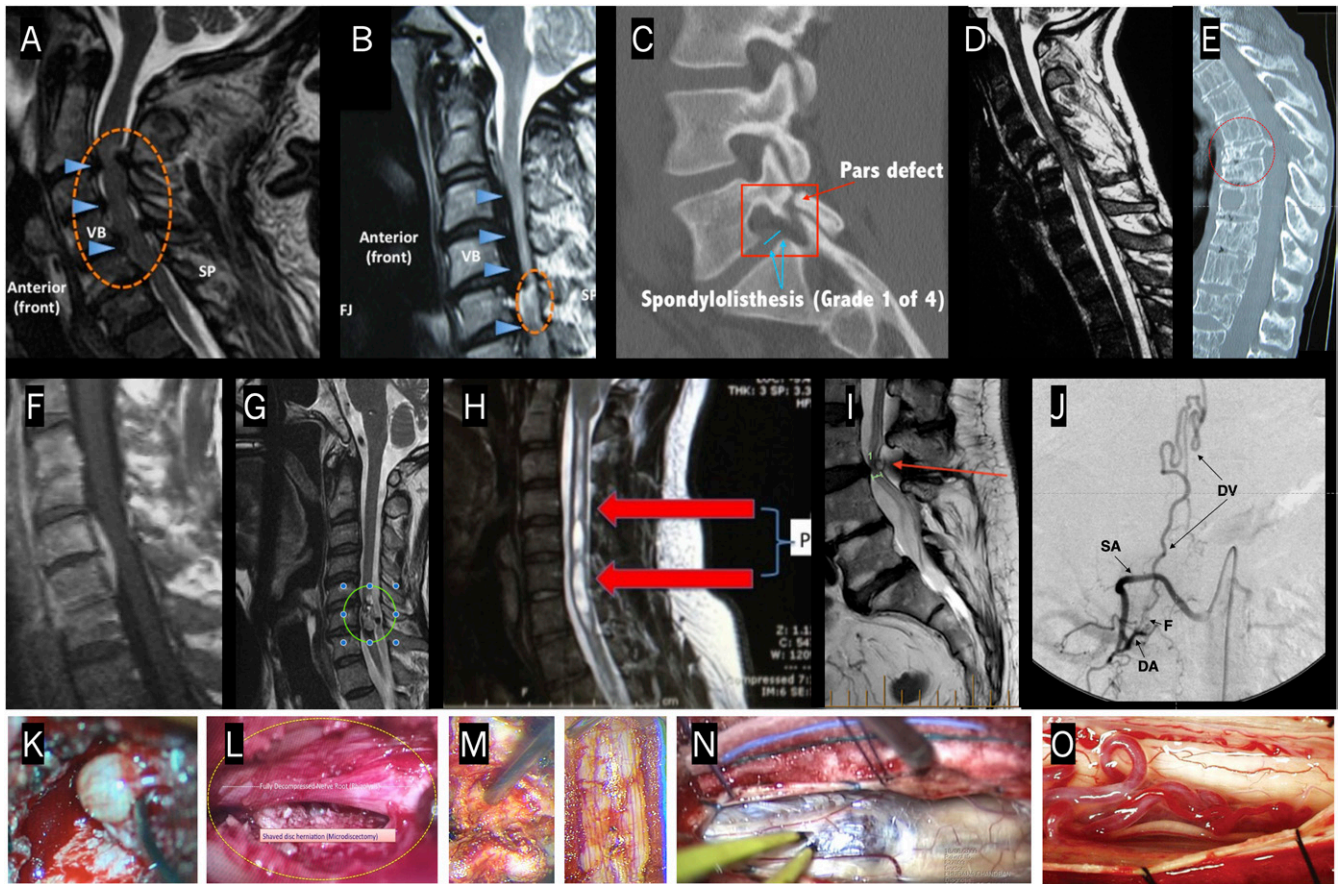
Some structural spinal pathologies. A) MRI T2 sagittal; severe cervical stenosis in a patient presenting with quadriplegia following a fall. B) MRI T2 sagittal; severe cervical stenosis in a patient with ossification of the posterior longitudinal ligament. C) CT sagittal; congenital pars interarticularis defect resulting in a spinal 'slip' or spondylolisthesis prior to surgical reconstruction. D) MRI T2 sagittal; traumatic cervical spinal cord injury prior to surgical intervention. E) CT sagittal; pathological spinal fracture in a 'moth-eaten' spine infiltrated with multiple myeloma in a paraplegic patient. F) MRI T1 sagittal postcontrast; extradural abscess (differential was a meningioma). G) MRI T2 sagittal; cervical spinal cord cavernous malformation (differential was a glioma). H) MRI T2 sagittal; syringomyelia from untreated Chiari I malformation. I) MRI T2 sagittal; lumbar spinal stenosis from degenerative facet cyst prior to surgical decompression. J) Catheter angiogram; spinal dural arteriovenous fistula (SDAVF) prior to being shut down surgically. K) Intraoperative view of a 'pearly' lumbar facet cyst being excised. L) Surgically decompressed spinal nerve during lumbar microdiscectomy. M) Cervical spinal stenosis pre- (left panel) and post- (right panel) surgical decompression, with the right panel showing the dural covering of the posterior cervical spinal cord. N) Cavernous malformation of the cervico-medullary junction at the time of incision of the posterior midline spinal cord prior to excision of the lesion (dark discolored area). O) SDAVF with engorged tortuous draining vein on view at the time of its surgical disconnection (spinal dura opened and retracted with thin black sutures at bottom of photograph). See the online version of this article (<https://doi.org/10.3357/AMHP5744.2021>) for color.
